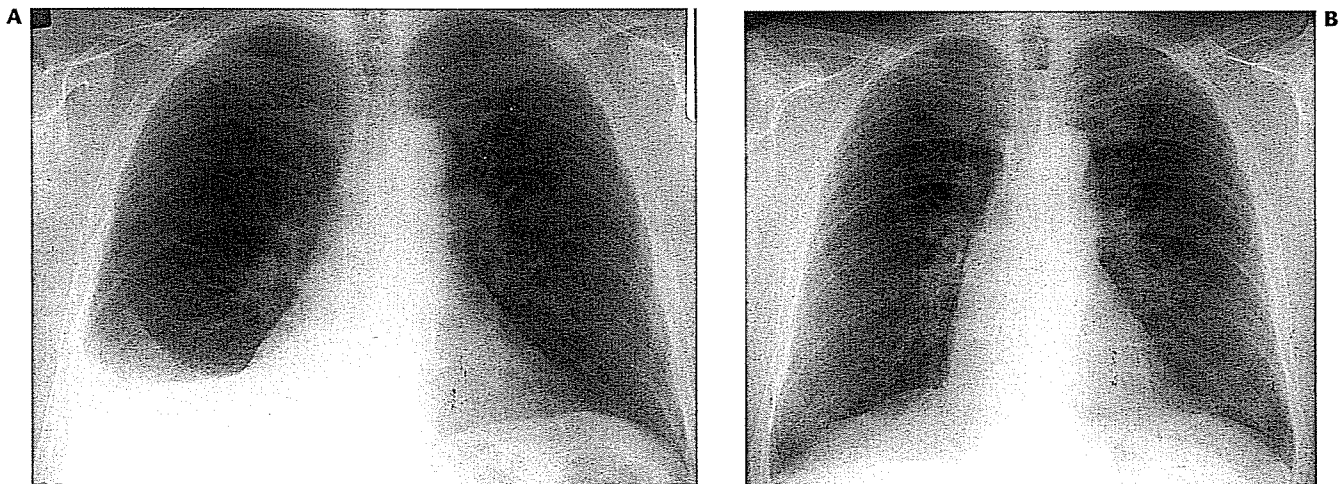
Diffuse pleural thickening occurring as a sequel of benign asbestos related effusion. A, Chest radiograph shows an asymptomatic benign asbestos related effusion on the right. B, Chest radiograph 5 years later shows clearing of the effusion, but residual pleural thickening evident by blunting of the right costophrenic sulcus.
